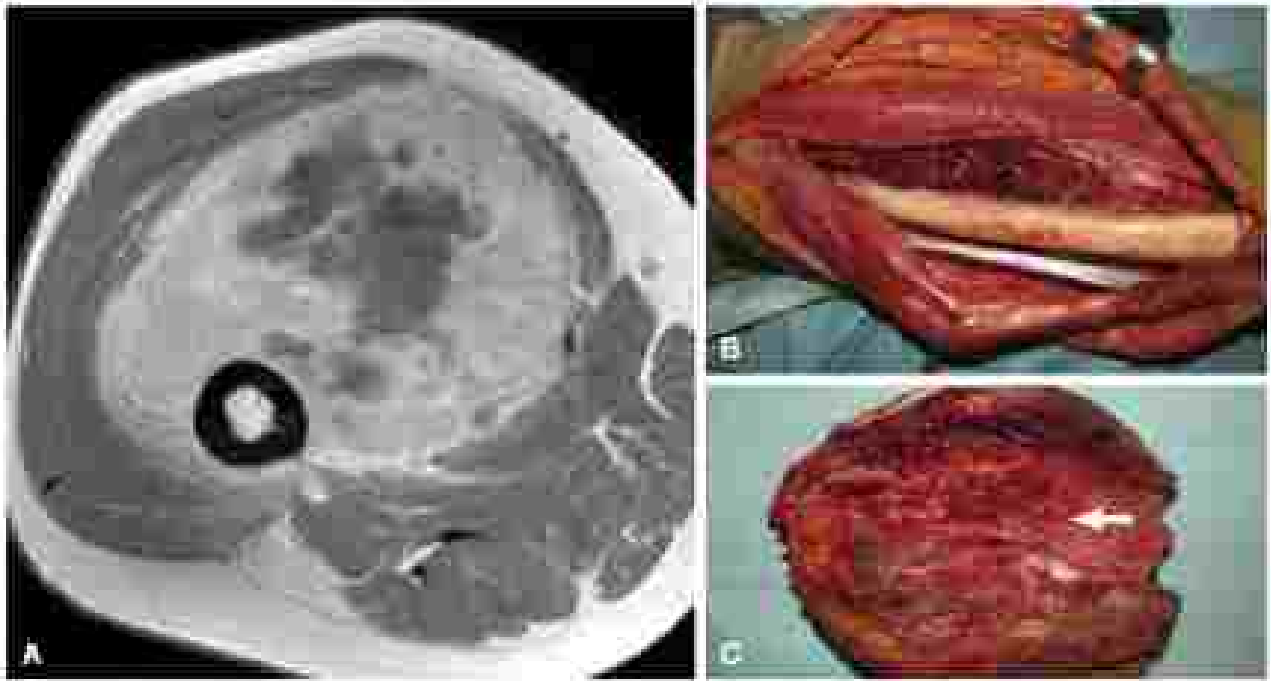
(A) Axial magnetic resonance image of a well-circumscribed pleomorphic sarcoma of the anterior compartment of the thigh partially encasing the femoral shaft. The patient received preoperative concurrent chemotherapy (3 courses of adriamycinol + ifosfamide) and radiotherapy (to a total dose of 50 Gy). (B) Intraoperative view of the tumor. (C) Intraoperative view of the surgical field with vascular replacement of both artery and vein.
